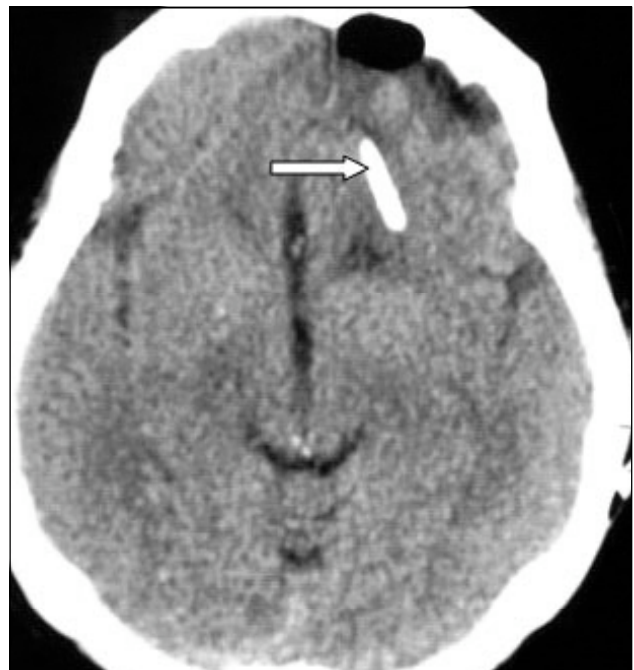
A postoperative CT showed the shunt catheter tip in the remnant cystic area.
